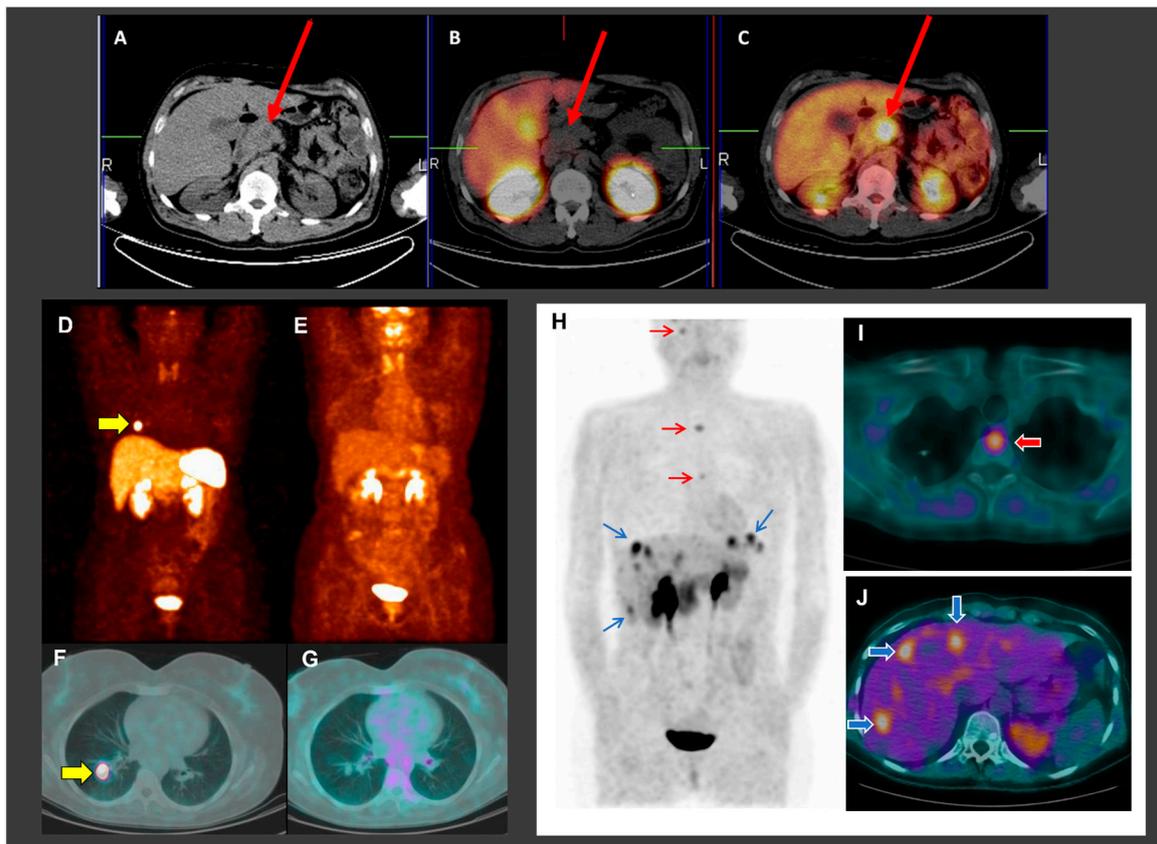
Case examples of the application of PET with different radiopharmaceuticals to detect neuroendocrine neoplasms. Axial computed tomography (CT) (A), hybrid somatostatin receptor imaging/CT (B) and fluorine-18 fluorodeoxyglucose positron emission tomography/CT (¹⁸F-FDG PET/CT) (C) in a patient with high grade pancreatic neuroendocrine tumor (NET) showing increased ¹⁸F-FDG uptake (increased glucose metabolism) and low uptake of radiolabeled somatostatin analogues (reduced expression of somatostatin receptors) due to its aggressive behavior. Somatostatin receptor PET (D), ¹⁸F-FDG PET (E), axial somatostatin receptor PET/CT (F) and axial ¹⁸F-FDG PET/CT images (G) in a patient with well-differentiated thoracic NET (typical bronchial carcinoid) showing increased uptake of radiolabeled somatostatin analogues (yellow arrows) due to increased somatostatin receptor expression and reduced ¹⁸F-FDG uptake due to reduced glucose metabolism. ¹⁸F-FDOPA PET (H) and axial ¹⁸F-FDOPA PET/CT images (I,J) showing bone metastases (red arrows) and liver metastases (blue arrows) with increased radiopharmaceutical uptake in a patient with recurrent medullary thyroid carcinoma (with increased serum calcitonin levels).
